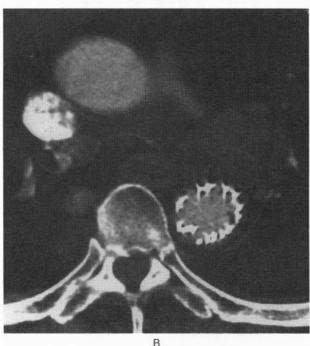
Axial CT Images Inferior to the Transverse Aortic Arch in a 77-Year-Old Man (Patient 9) with Previous Coronary-Artery Bypass Grafting and Recent Hoarseness Associated with an Aneurysm of an Aortic Ductus Diverticulum.
